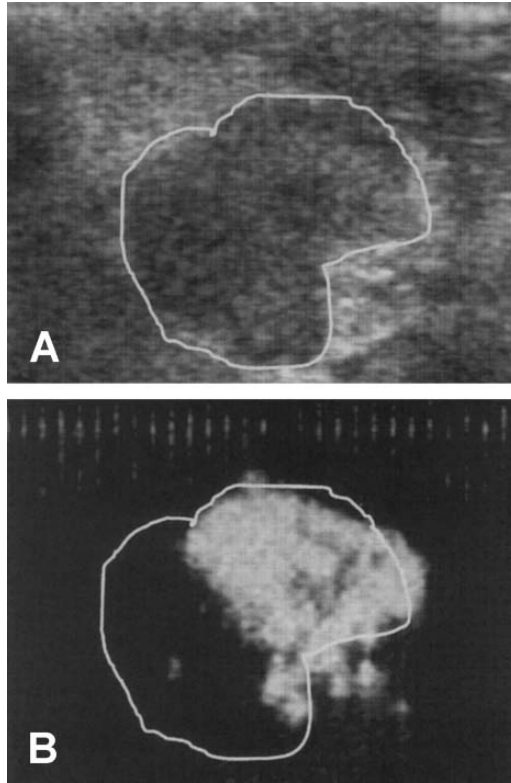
Metastatic popliteal lymph node in a rabbit implanted with VX2 carcinoma. A Standard grayscale image. B Burst image of the same node acquired following a 30 second delay. The portion to the right represents normal nodal tissue that accumulates contrast microbubbles. Insonation causes bubble rupture and an intense signal response. The segment on the *left* is replaced by tumor resulting in a contrast-filling void. Reproduced with permission from Mattrey (2002). Reprinted from Mattrey et al., 2002. Sentinel lymph node imaging with microbubble ultrasound contrast material. *Acad Radiol* 9 Suppl 1, S231–235 with permission of Association of University Radiologists.
